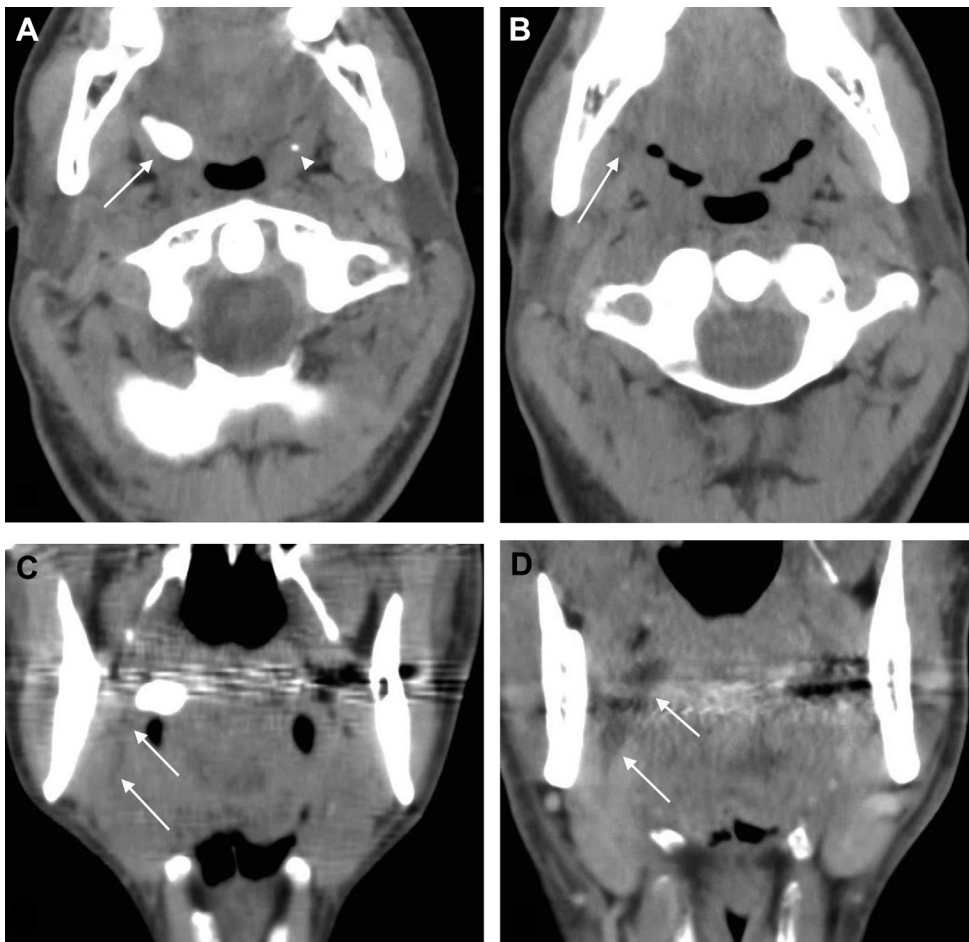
Axial noncontrast neck computed tomography (CT) performed at an outside institution revealed a $17 \times 10 \times 12$ mm calcification in the right tonsillar fossa (A, arrow) and a punctate calcification on the left (A, arrowhead). On the right, ductal distention in the right submandibular gland was not prospectively recognized to extend to the calcification (B and C, arrow). After right tonsillectomy and stone removal, the patient had continuing right submandibular swelling. Subsequent neck CT with contrast revealed increased size of the fluid tract from the right submandibular gland to the right parapharyngeal space (D, arrow), which was then excised.
